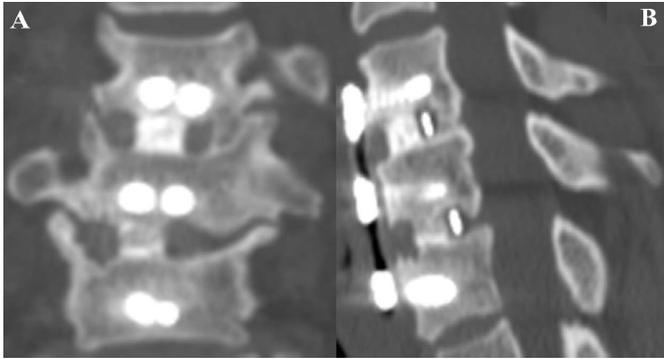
Example of anterior cervical discectomy and fusion. (A and B) Coronal and sagittal computed tomographic scans of a 51-year-old woman, 20 months after the procedure.
